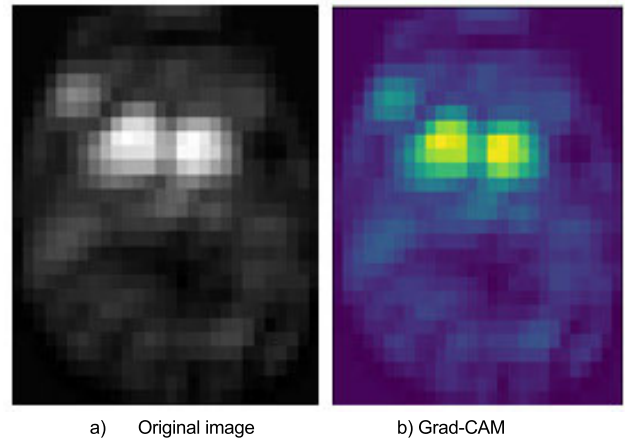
Comparison of SPECT Images of HC from D1 with attention maps generated using Grad-CAM Algorithm for the custom CNN.
